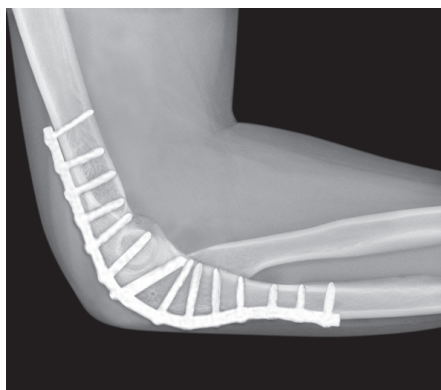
X-ray: Elbow arthrodesis with plate and screw
